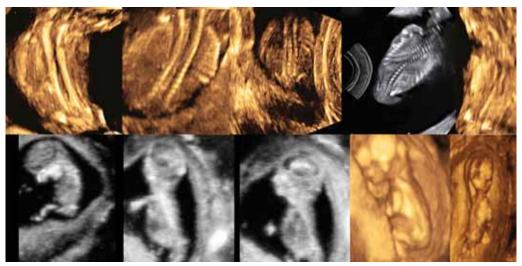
Fetal spine can be evaluated successfully at the first trimester by 2D (above line) and 3D ultrasound VCI technique (bottom first 3 pictures) and 3D surface rendered image (last 2 on the right at the bottom line)
